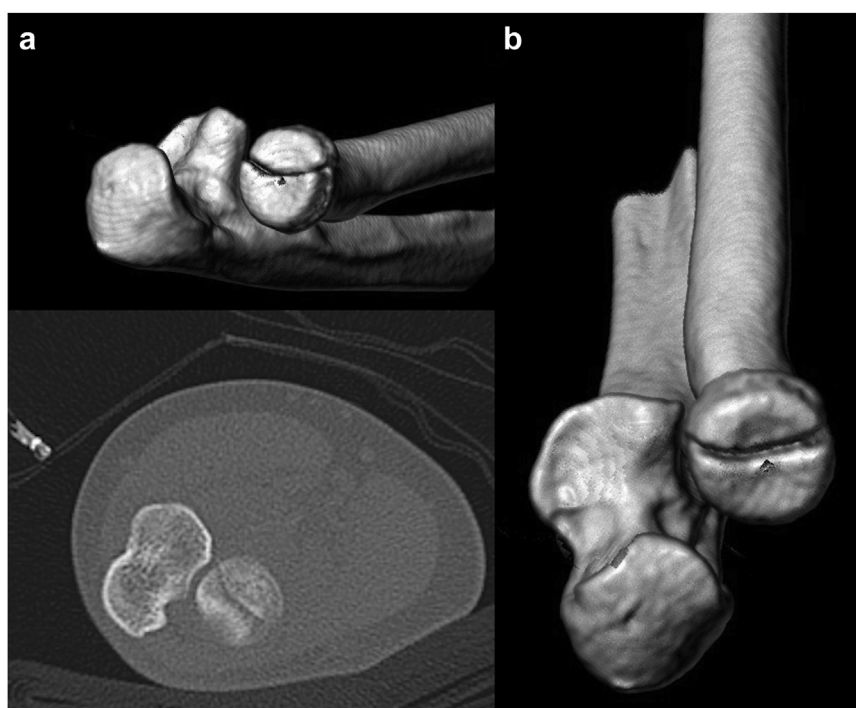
Type B subtype B2 fracture. (a) CT axial view of PARFs with displacement, without complete loss of cortical contact, involving the APRH. (b) Three-dimensional CT reconstruction. CT, computed tomography; PARF, partial articular radial fractures of the radial head; APRH, articulating portion of the radial head.
